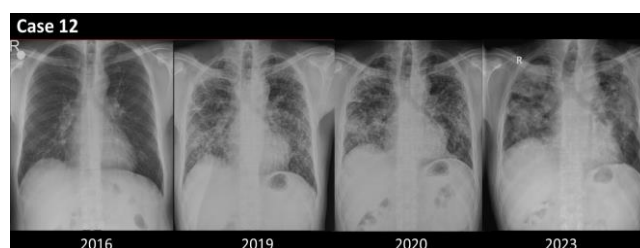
Chest x-ray images of Case 12. Rapid progression is observed over approximately seven years
